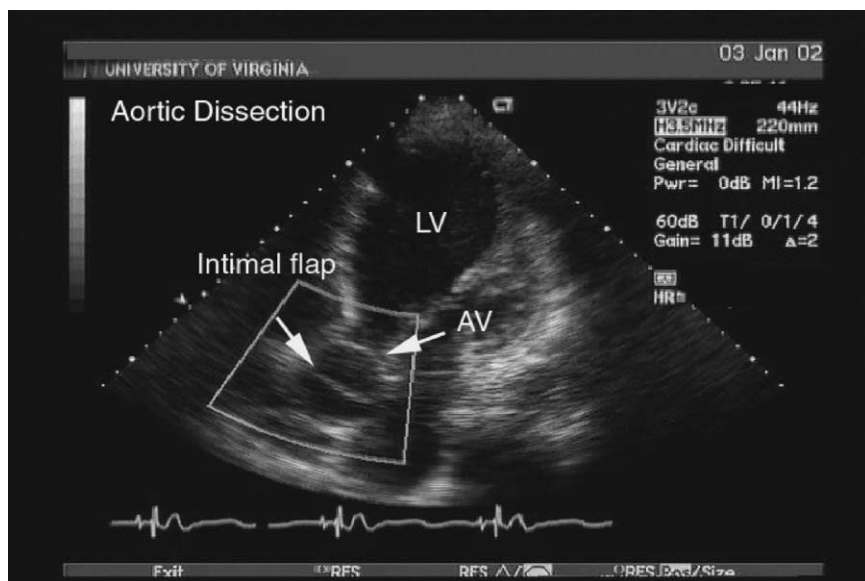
Two-dimensional echocardiogram of a patient with Marfan syndrome who experienced an acute aortic dissection. The intimal flap can be seen just above the aortic valve in this inverted image. Sudden death can be precipitated by pericardial tamponade, although this patient had no evidence of pericardial effusion.
